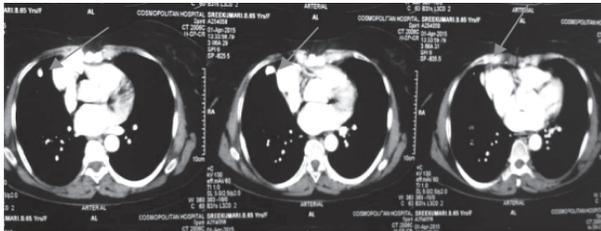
CT Contrast showing a well taken contrast lesion near the right cardiac phrenic angle.
